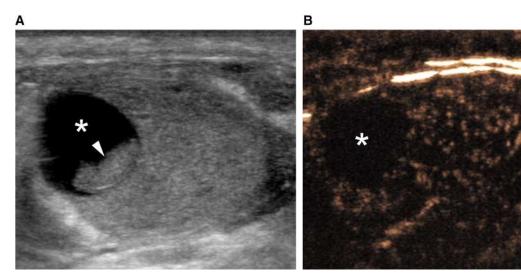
Incidentally detected complex testicular cyst. A Gray-scale ultrasonography shows a complex cyst in the upper pole of the testis (asterisk) containing echogenic
